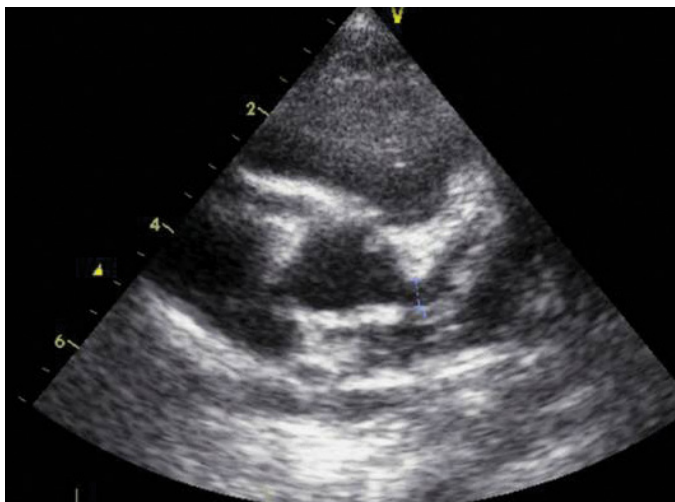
Echocardiographic demonstration of the right and left coronary artery dilatation because of Kawasaki disease
